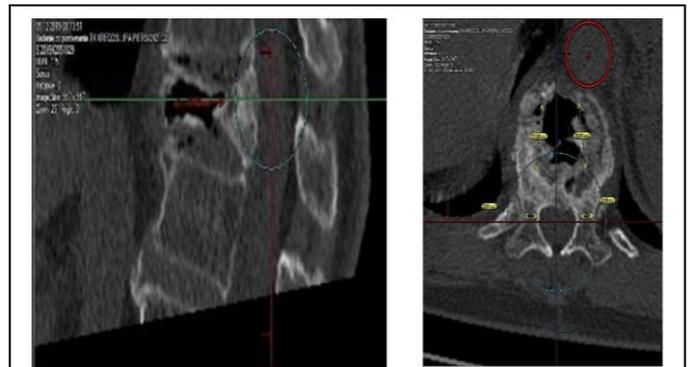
CT images of the vertebrae injured from OVCF of a patient with developed KD after a usage of conservative treatment.
